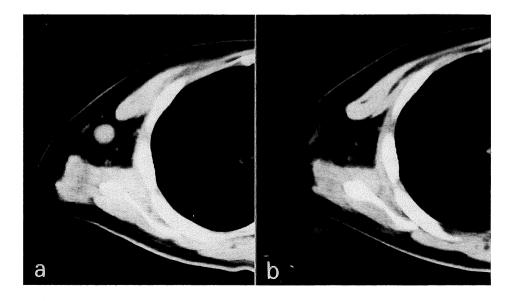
Case 16. Metastasis to the axillary lymph node was detected by CT scan (a). Metastatic lesion had almost disappeared after administration of 1 course of IFOS, etoposide, and high dose of CPM (b).
